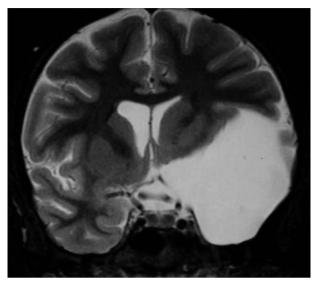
Coronal T2-weighted MR image showing a Sylvian arachnoid cyst with midline shift and ventricular compression
